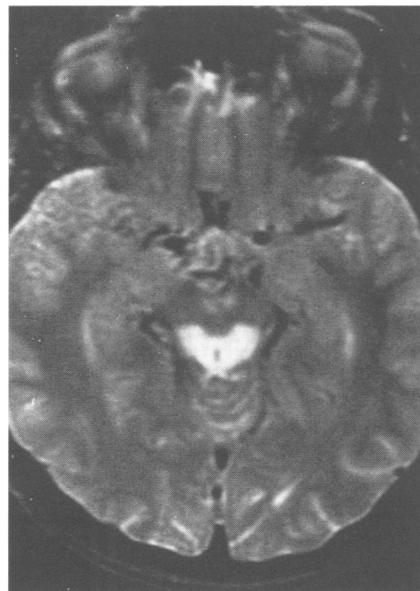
Axial T2 weighted MRI, showing a symmetric lesion of the dorsal midbrain (maximum size, January 1993).
